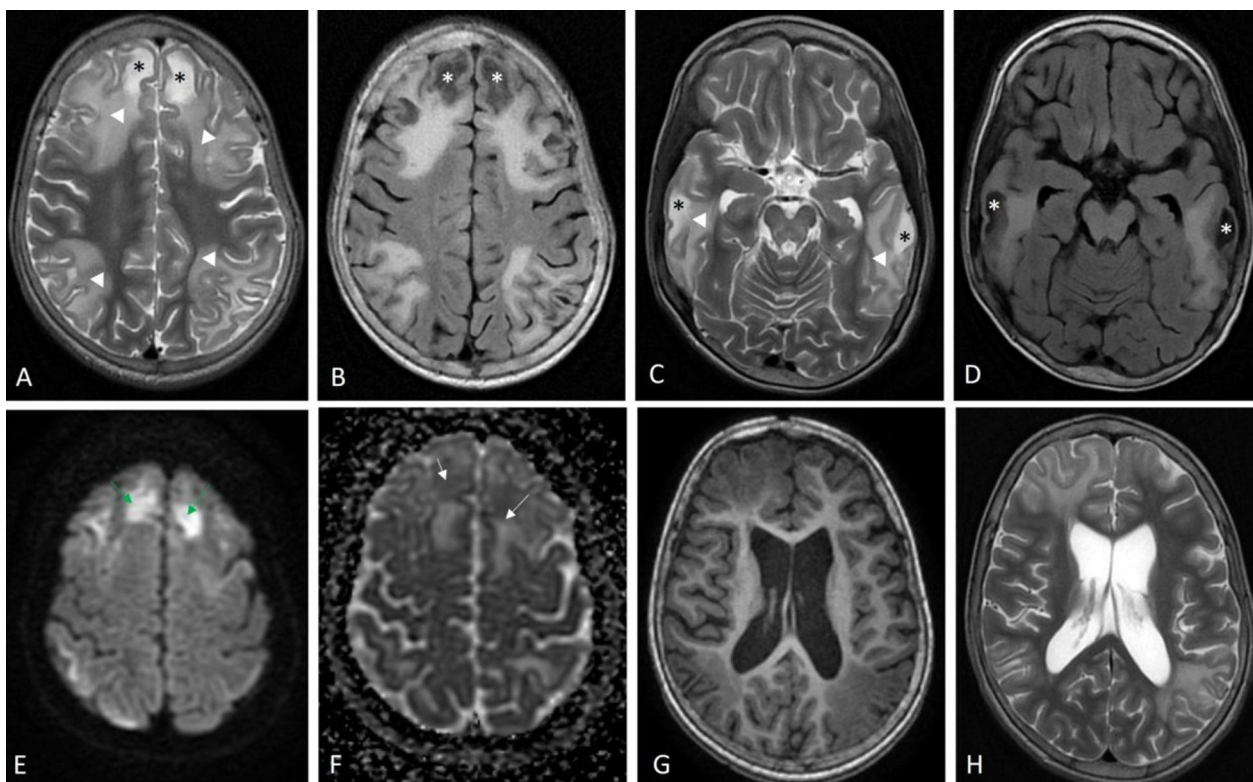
Axial T2 weighted MR images (A and C) and axial T2 FLAIR MR images (B and D) show bilateral, symmetrical, confluent white matter hyperintensities in the frontal, parietal and temporal lobes (white arrow heads). Symmetrical T2 hyperintense (black asterisks) and T2 FLAIR hypointense (white asterisks) subcortical cystic areas seen in bilateral frontal and temporal lobes. Axial b=1000 DWI image (E) and corresponding ADC map (F) shows focal areas of diffusion restriction in bilateral frontal white matter. Axial T1 weighted and T2 weighted MR images at the level of lateral ventricles (G and H) show cerebral atrophy in the form of mildly prominent bilateral lateral ventricles
